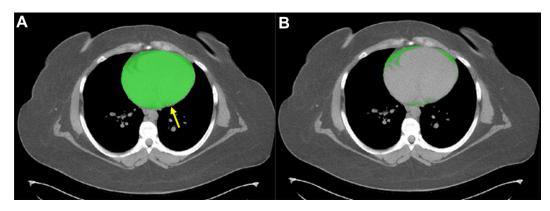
A, B, Delineation of epicardial adipose tissue on chest CT scan. A, Automated mask delineation of heart and epicardial adipose tissue deep to the pericardium with manual correction on axial CT chest image. Surrounding paracardial fat (arrow) is excluded. B, Axial CT slice showing epicardial adipose tissue delineated, after removal of non-epicardial adipose tissue and myocardium from original mask.
